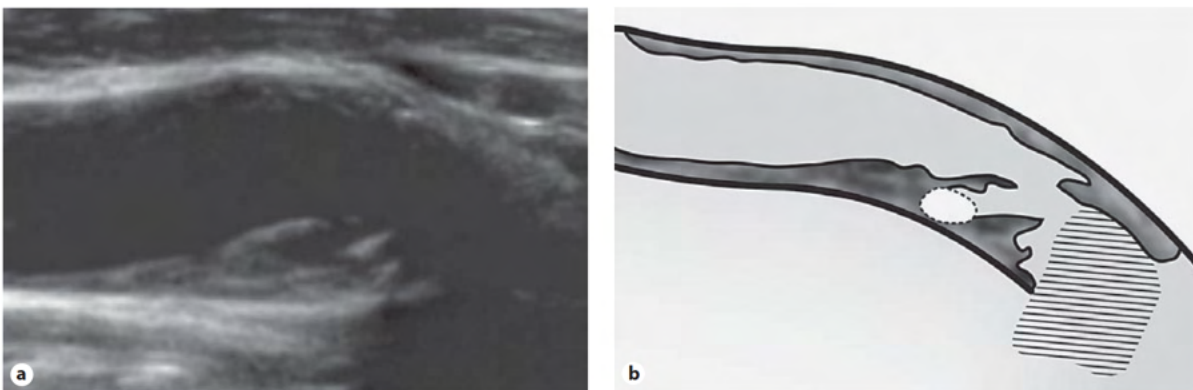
Fluctuating-ulcer-type plaque seen by supra-aortic trunk ultrasound (A) and its scheme (B) (36).
